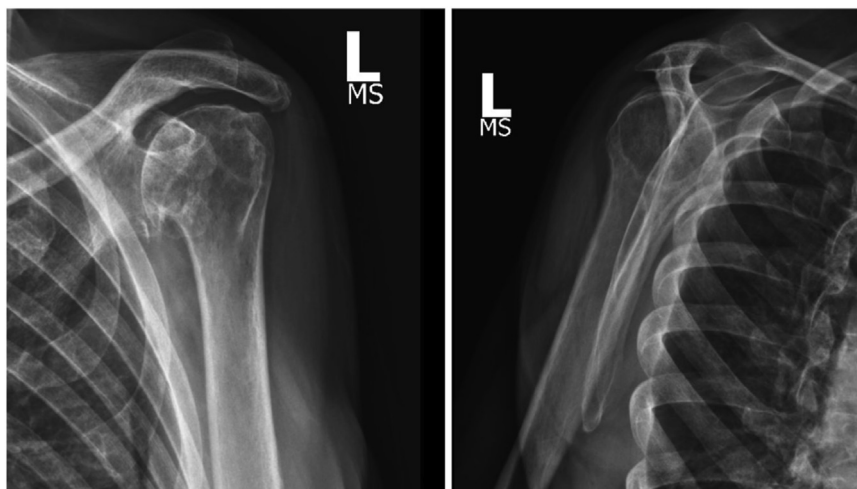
Preoperative X-rays showing end-stage glenohumeral arthritis with posterior subluxation of the humeral head. The amount of subluxation is suspicious for glenoid hypoplasia.
